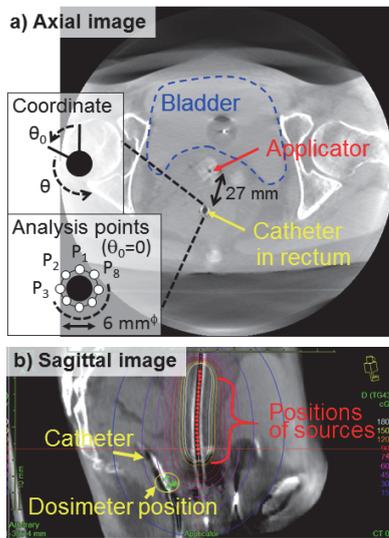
Typical result of X-ray images used in clinical treatment. Upper and lower images indicate axial and sagittal views (see text).
